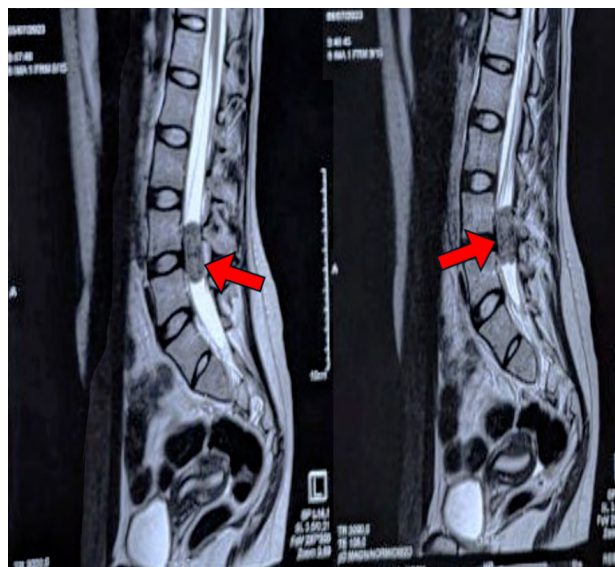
Preoperative lumbar spine magnetic resonance imaging. The red arrow indicates the intradural extramedullary lesion at the L3–L4 level.
